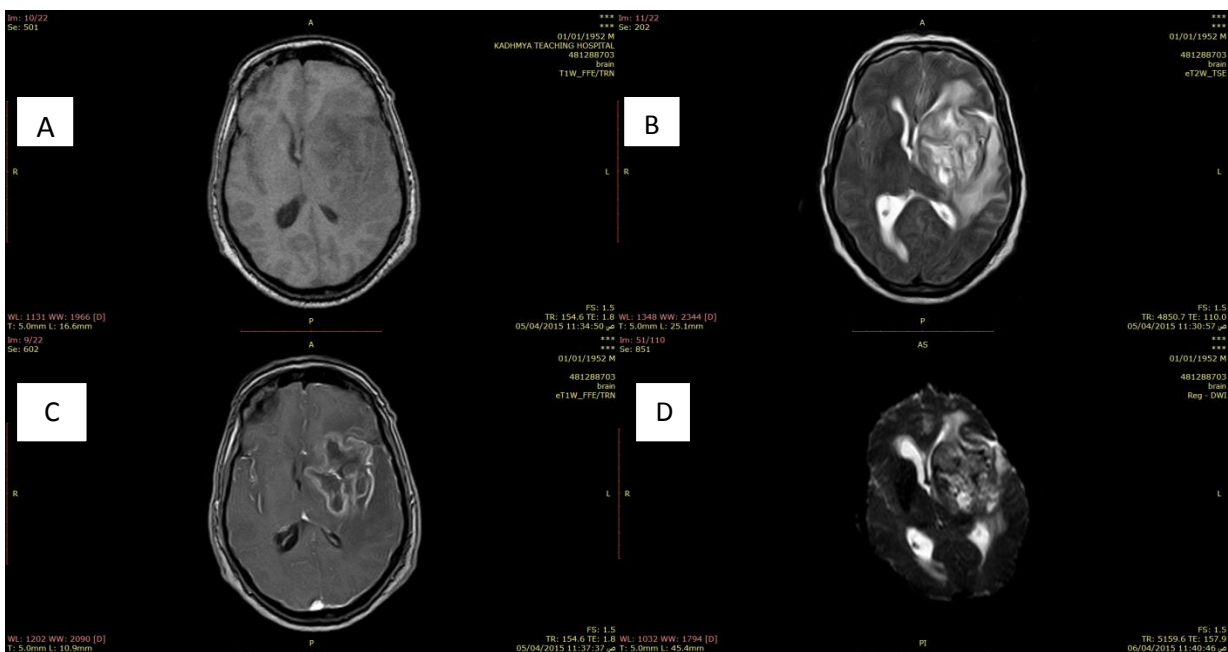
47-year-old male patient with left parietal mass (A. T1 axial; B.T2 axial; C.T1 axial postcontrast; D. DWI; E. ADC) showing ring enhancement and non-restricted diffusion with maximal ADC values (2.32 x10-3) and biopsy-proven GBM.
